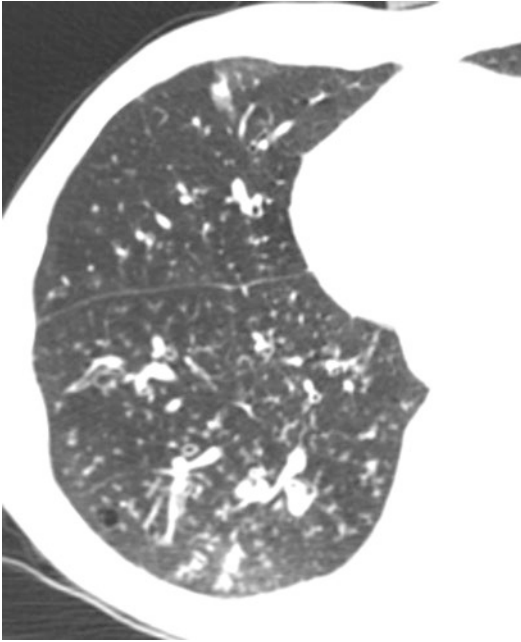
CT axial scan evidences multiple centrilobular nodules and peribronchial inflammation with centrilobular distribution
